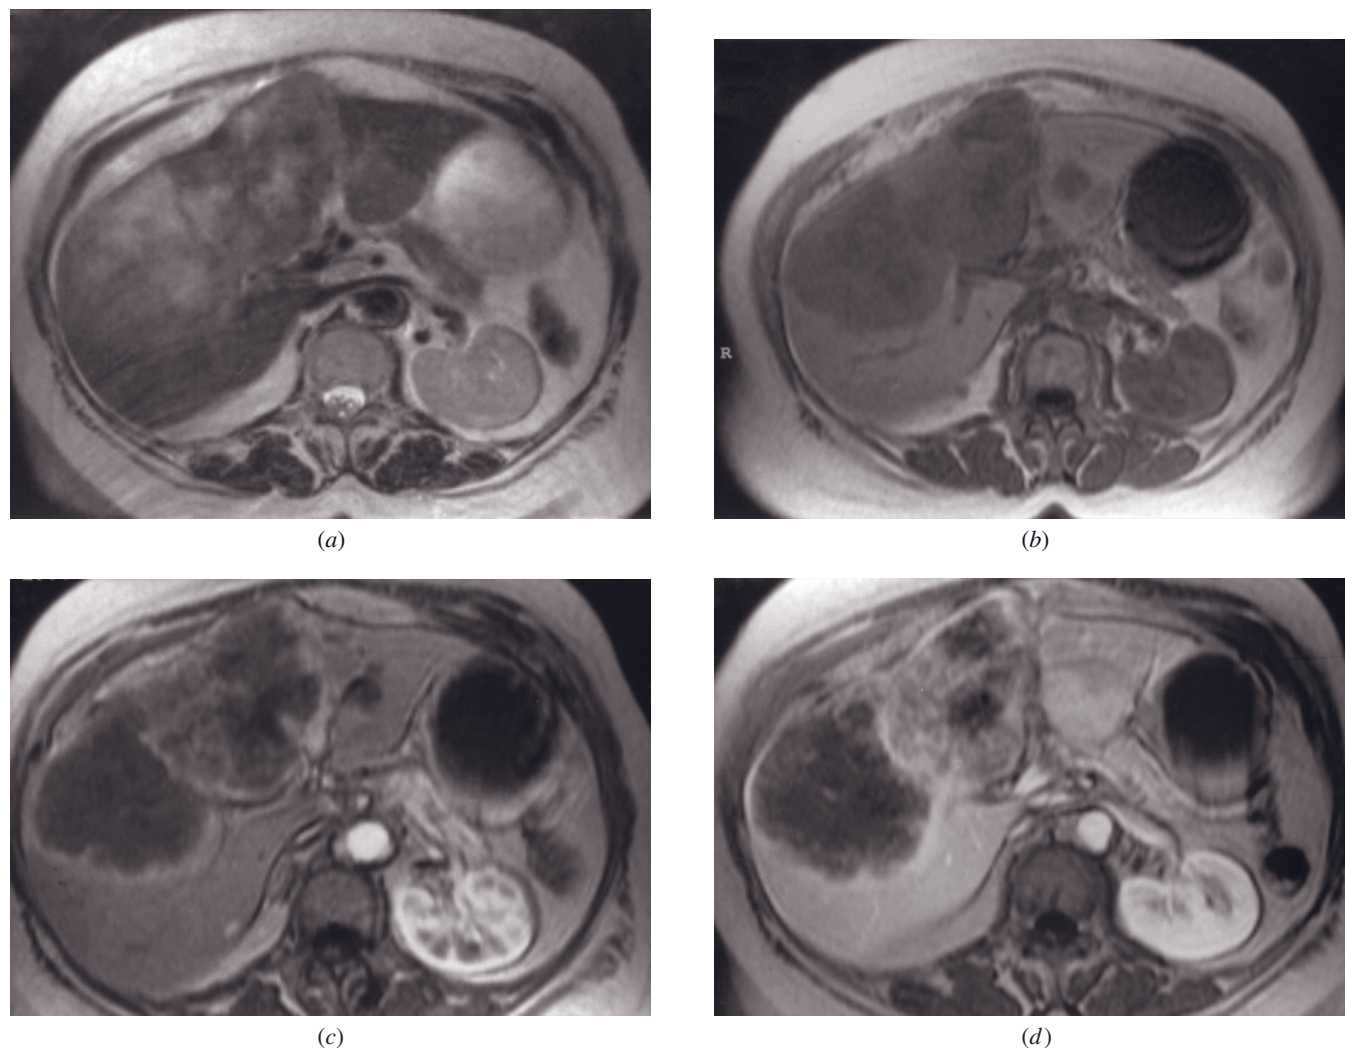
Hepatic alveolar echinococcosis. T2-weighted ETSE (a), SGE (b), and immediate (c) and 90-s (d) postgadolinium SGE images. A large lesion with irregular margins is present in the liver that demonstrates mildly high signal on T2-weighted image (a) and low signal on T1-weighted image (b), and a peripheral rim of enhancement on early-phase image (c) that persists on late images (d). There is a substantial solid component within the large infective lesion. The lesions exhibits ill-defined margins. (Courtesy of N. Cem Balci, M.D.)
